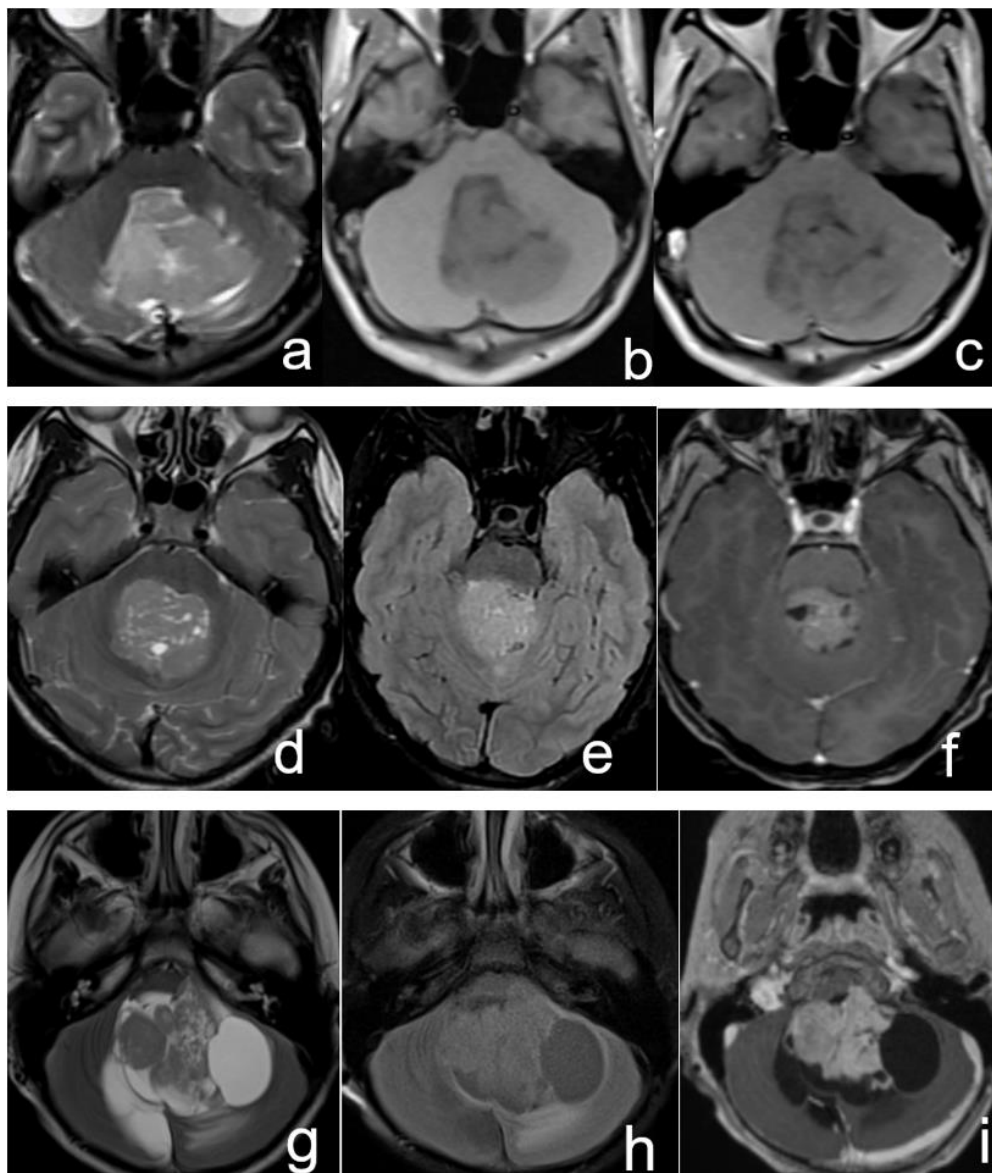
Examples of MRI features of medulloblastomas:
